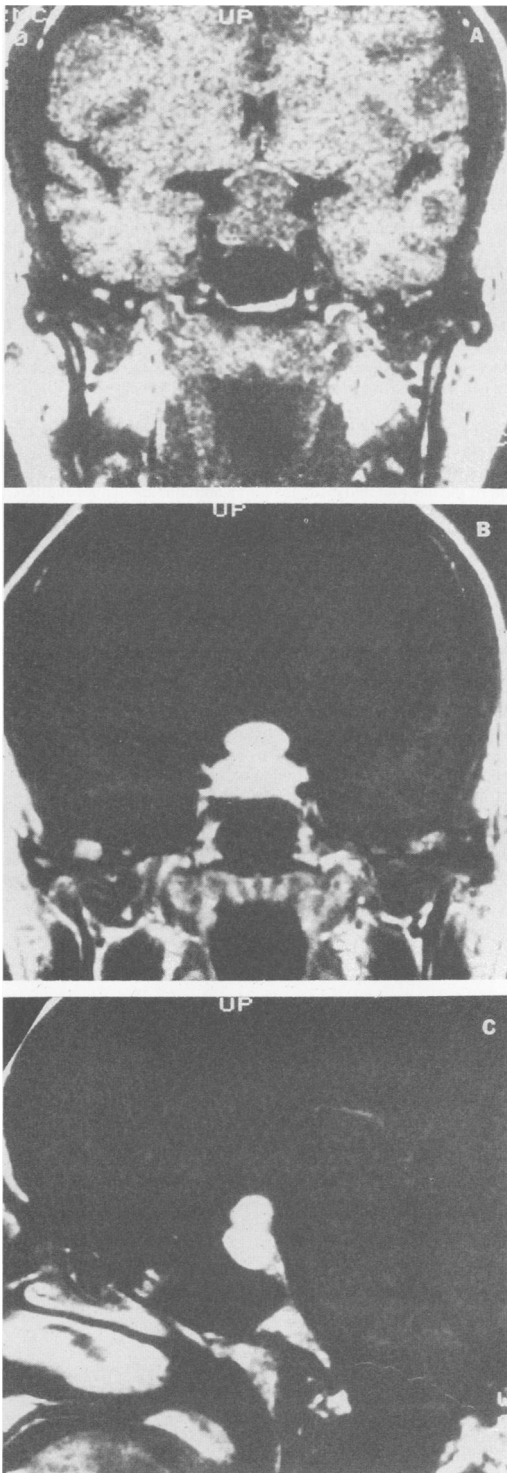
T1-weighted magnetic resonance imaging of the head of a patient with lymphocytic hypophysitis 1 month postpartum. (A), A coronal view without contrast shows an hourglass-shaped pituitary mass with suprasellar extension compressing the optic chiasm. (B), A coronal view after the administration of 14 ml of gadopentetate dimeglumine (Magnevist) shows pronounced enhancement of the tumor. (C), A sagittal view after Magnevist was administered shows tumor enhancement.
